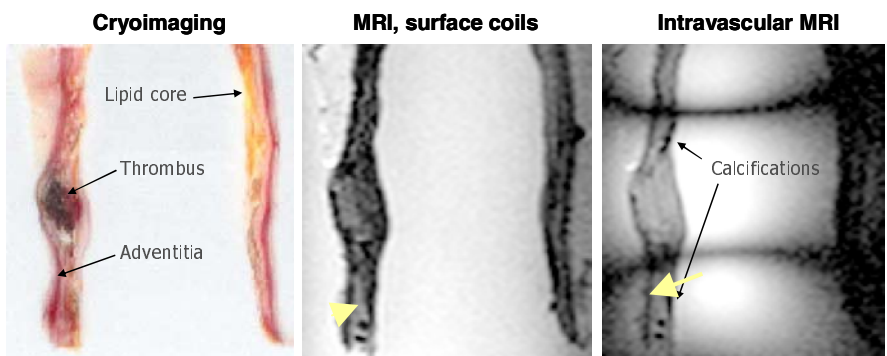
Sagittal view of one *ex vivo* sample. Left panel shows the cryoimaging volume where different tissues can be identified. Middle and right panels show the corresponding sections from the registered MRI TrueFISP volumes (intravascular MRI is log transformed). Arrow and Arrow head have been put on Adventitia and Media layers.
